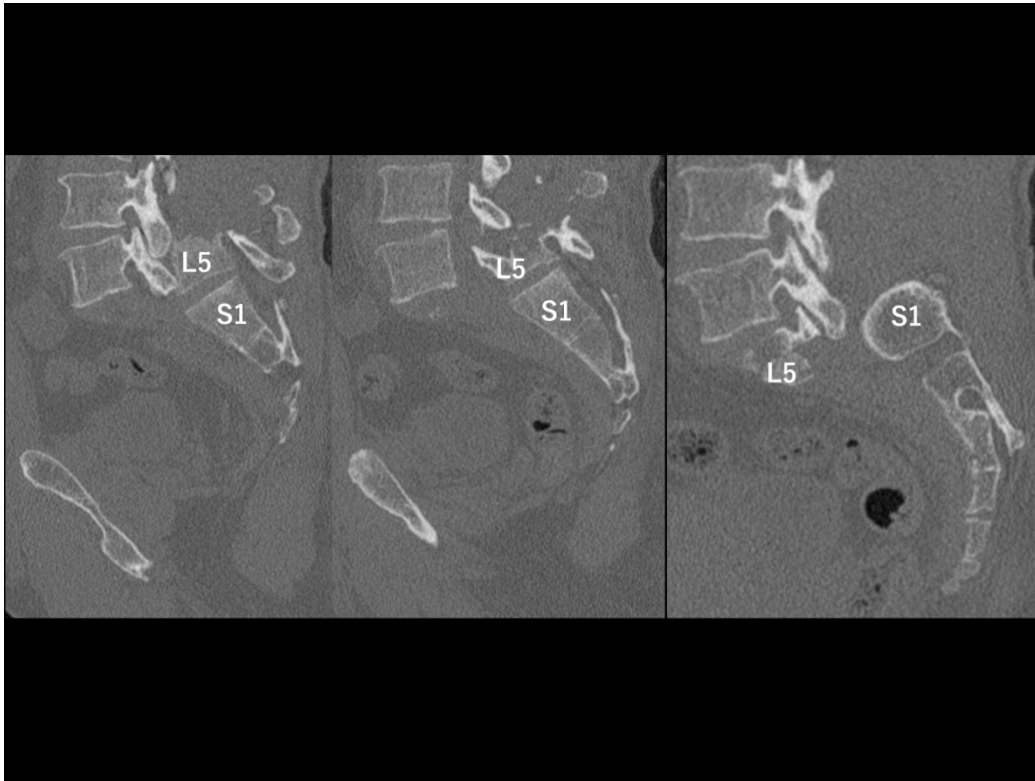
Sagittal view of computed tomography (CT) on arrival (bony density image). CT revealed complete L5/6(S1) anterior dislocation fracture
